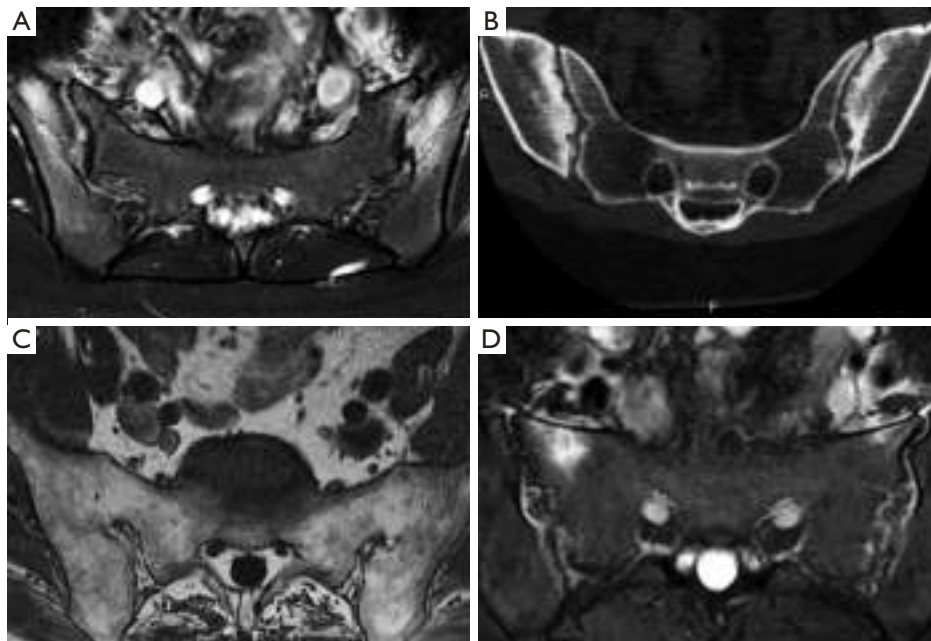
Sacroiliitis in four patients. (A) Axial STIR in active inflammatory spondyloarthropathy. (B) CT showing structural changes at the sacroiliac joints. (C) T2 weighted image of a patient with chronic sacroiliitis with fused joints. (D) Axial STIR sequence image of a patient with post-partum subchondral edema at both iliac wings. STIR, short tau inversion recovery; CT, computed tomography.
